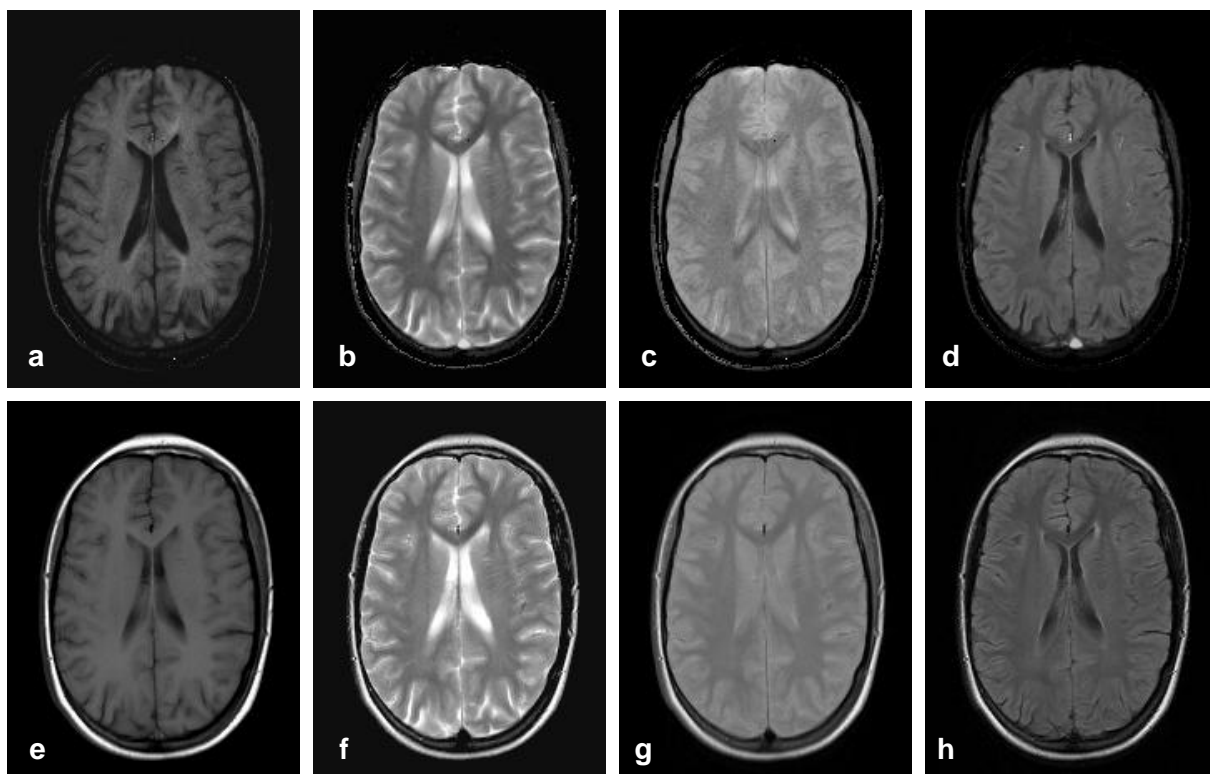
Representative results obtained in subject #1 of Table 6.2. Synthetic images: (a) T_1 -weighted with $TE/TR = 14/500$ ms, (b) T_2 -weighted with $TE/TR = 98/4000$ ms, (c) spin density-weighted with $TE/TR = 16/4000$ ms, and (d) FLAIR with $TE/TI/TR = 105/2200/6500$ ms; (e-h) corresponding acquired images from separate imaging sequences.
